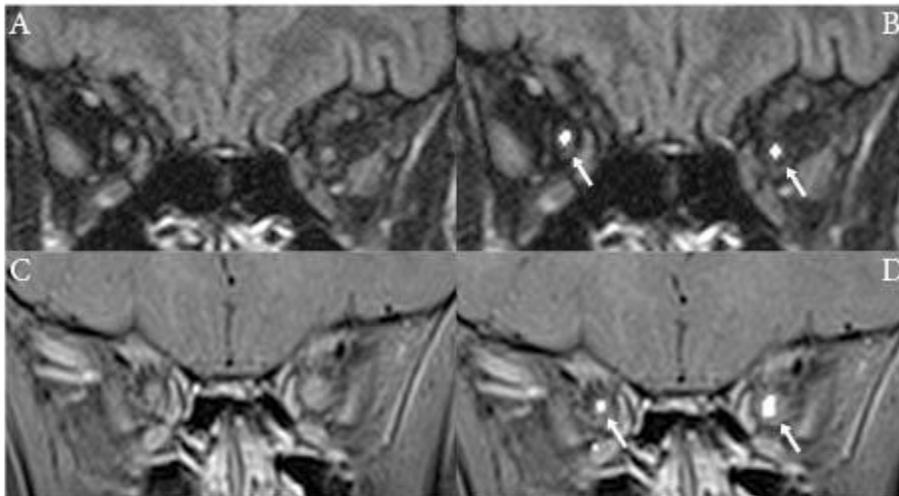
Representative coronal fat-saturated FLAIR (A,B) and coronal contrast-enhanced T1WI (C,D) from two different patients with concurrent bilateral optic neuritis before (A, C) and after (B, D) processing show accentuation of optic nerve signal intensity. In masked reads by 6 readers, detection rates of right (left) optic neuritis improved from 2 to 5 (4 to 5) on FLAIR and 2 to 5 (5, unchanged) on contrast-enhanced images.
